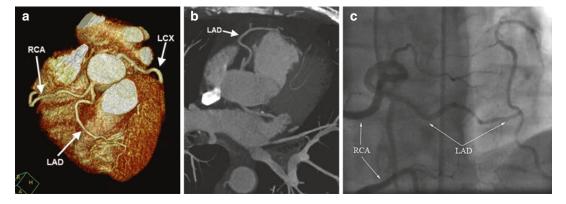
(a, b) VR. Axial MIP: LAD originating from the right sinus of Valsalva with an anterior (precardiac) course. (c) Right coronary angiogram performed prior to the CTA
